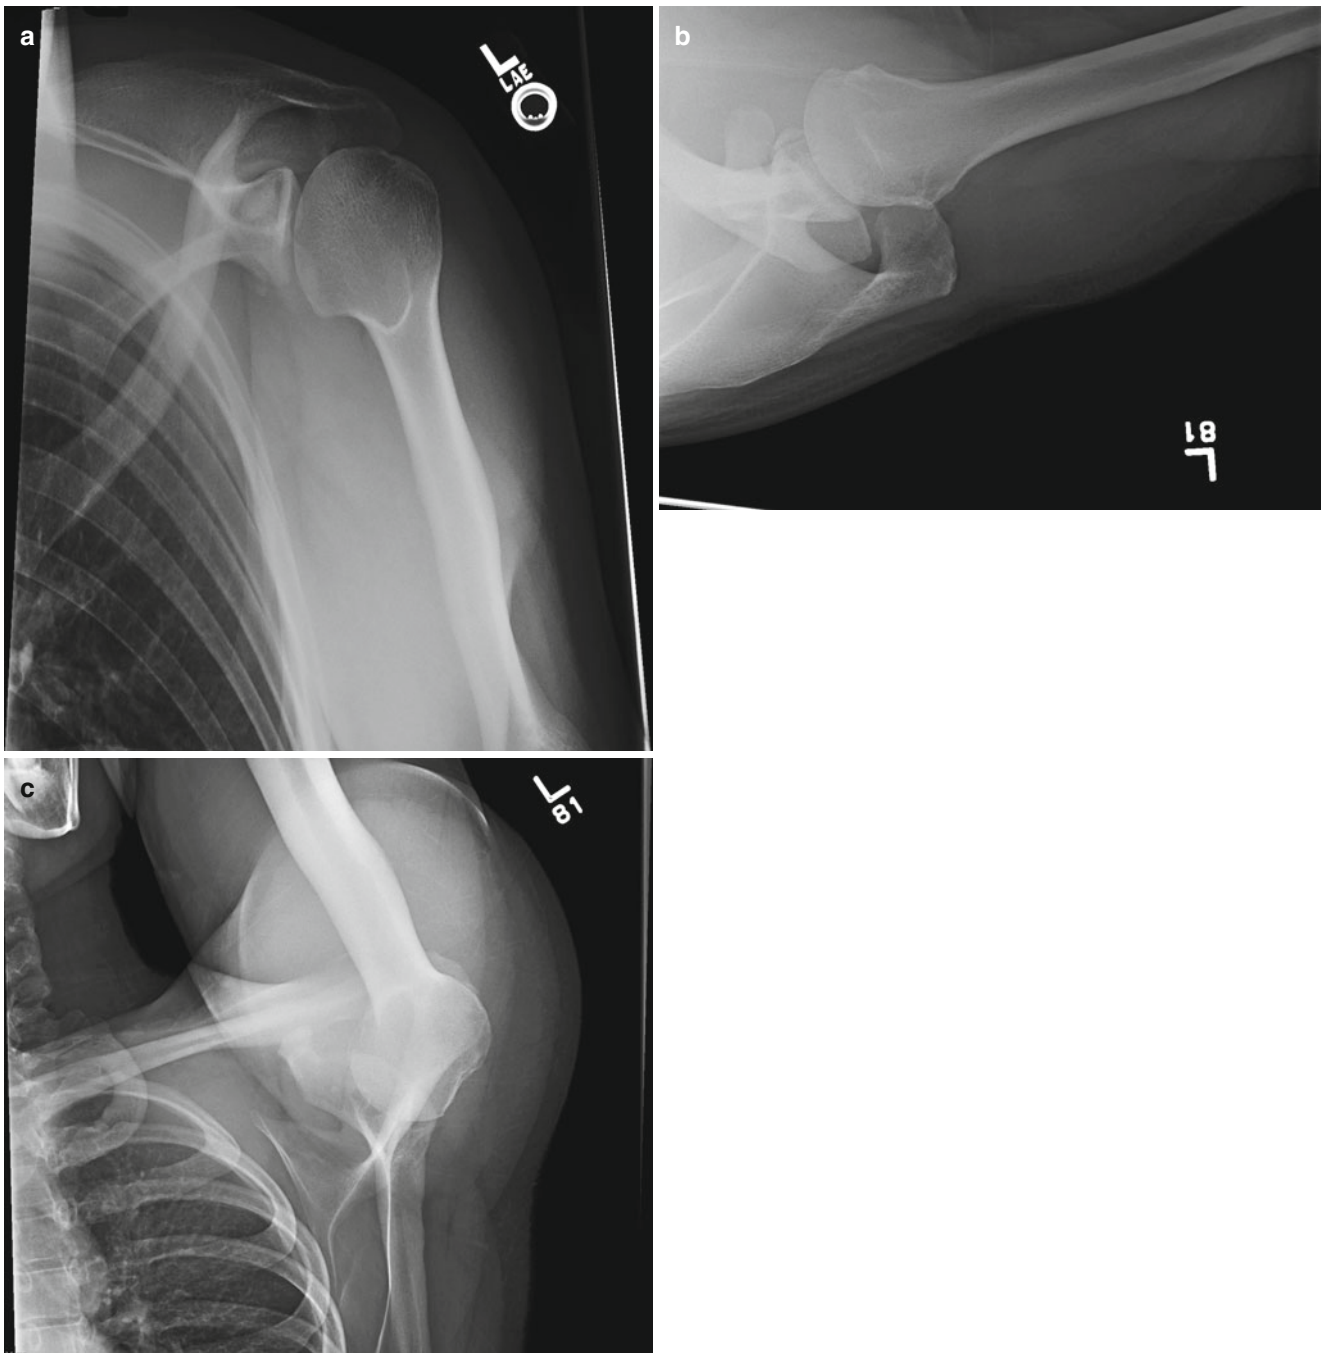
Plain radiographs demonstrating a true AP (a), West Point view (b), and Stryker Notch view (c) of the shoulder
